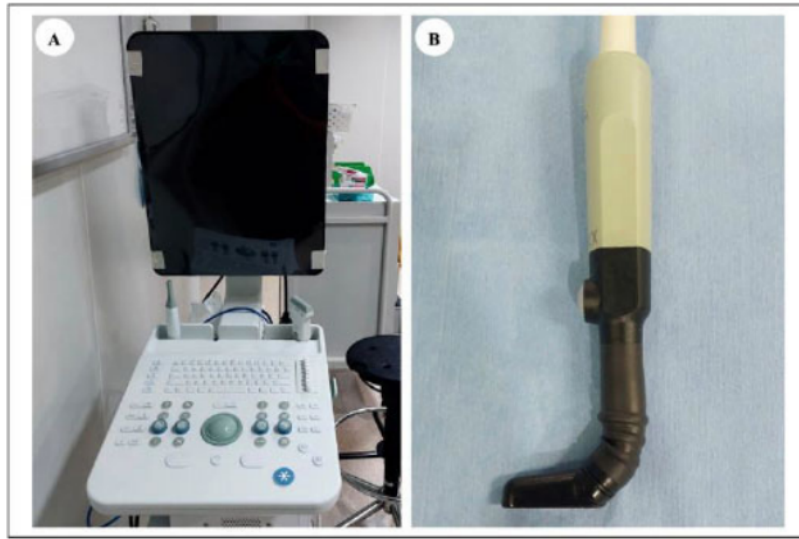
A. The ultrasonography device; B. The transducer.
